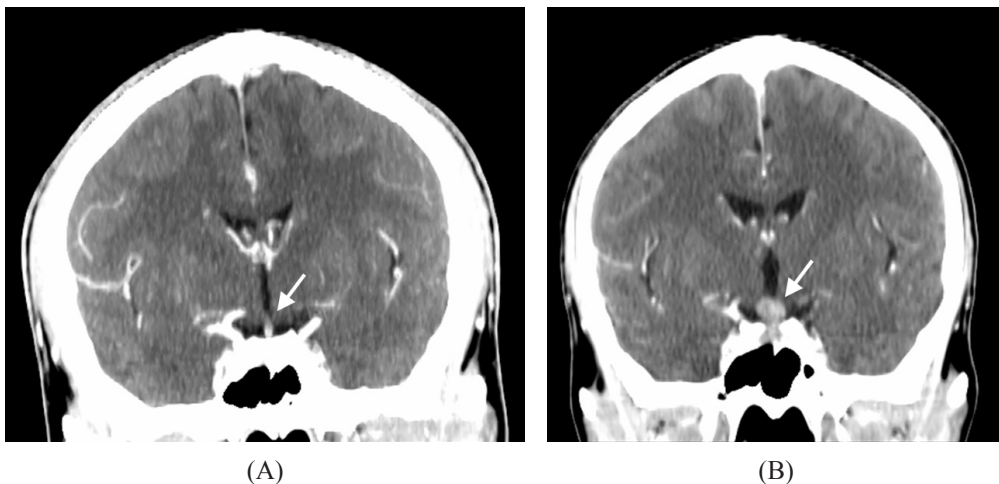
Computed tomography of the brain. (A) Computed tomography of the brain revealed no space-occupying lesion in the pituitary gland (arrow); image taken 6 months earlier. (B) A new contrast-enhanced pituitary tumor (arrow) protruding into the hypophyseal fossa while the patient developed polydipsia and polyuria. Effacement of the sulci indicated intracranial pressure might be increased in both figures.
